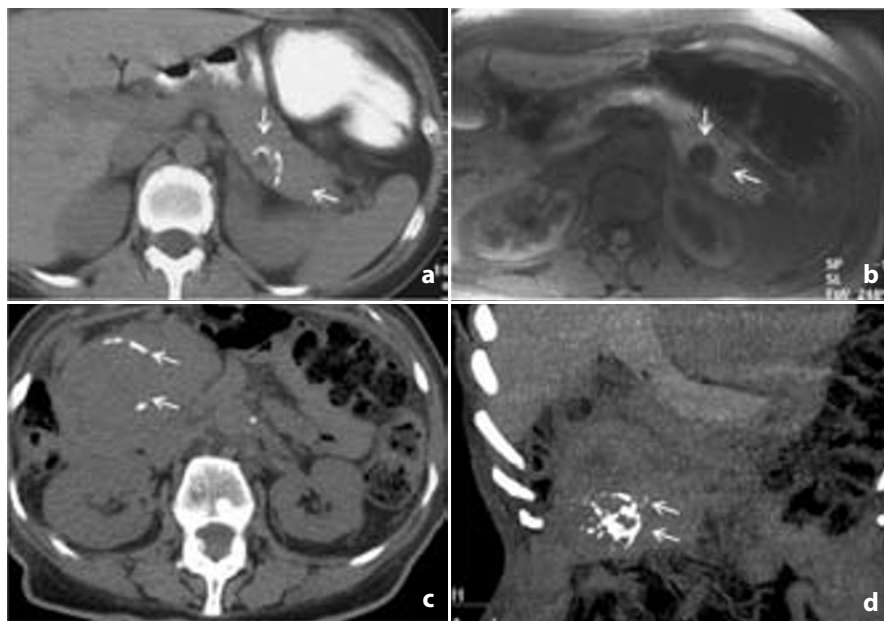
Calcification in PanNENs. Unenhanced CT scan points out a tiny F-PanNEN located in the pancreatic tail, with intralesional calcifications (a). These are not depicted on T1-weighted MRI (b). A large NF-PanNEN located in the pancreatic head, with intralesional calcifications depicted on unenhanced axial (c) and coronal (d) scans
